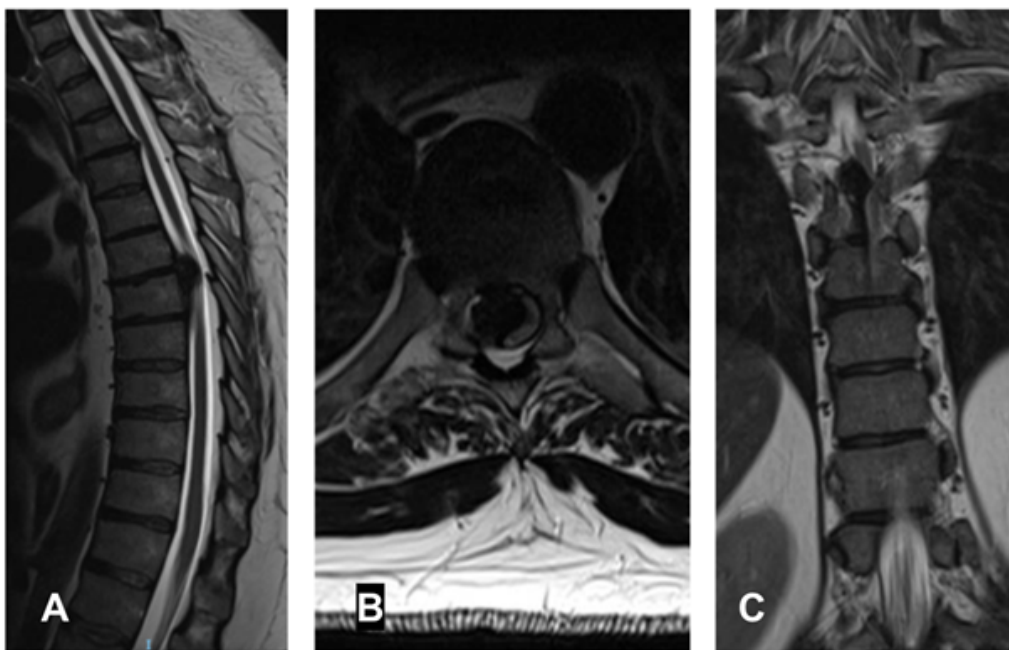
Magnetic resonance imaging of the spine, T2-weighted sequence, sagittal (A), axial (B), and coronal (C) section: osteochondroma in the spinal canal at the level of T6–T7, with spinal cord indicating compression.
